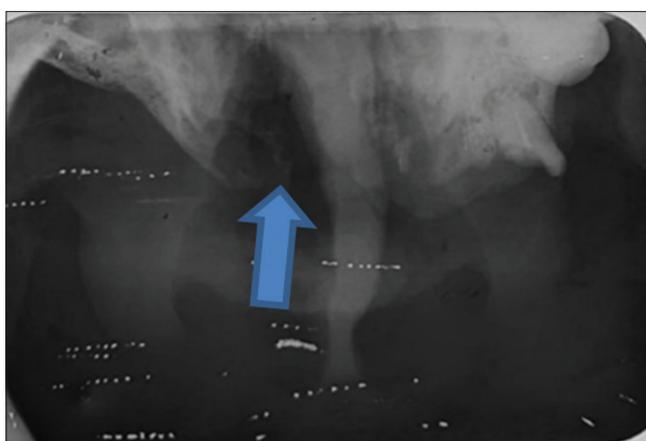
Occlusal radiograph show an ill-defined radiolucency involving maxillary bone extensively, bone appears to be moth-eaten
